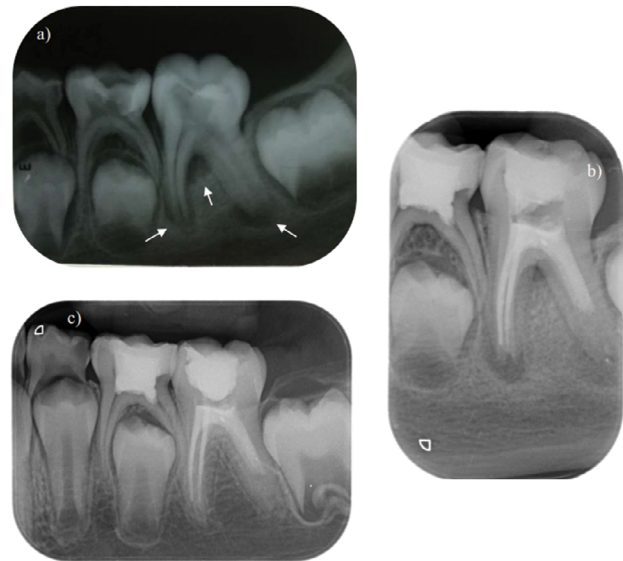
Healing of the periapical lesion without changes in the length of the root or closure of the apex. a) Initial X-ray with periapical lesions around both roots, as well as radiolucency in the interradiolar space (arrow); b) Follow-up after REP of the distal root and filling of the mesial canals; c) Follow-up after 24 months.
